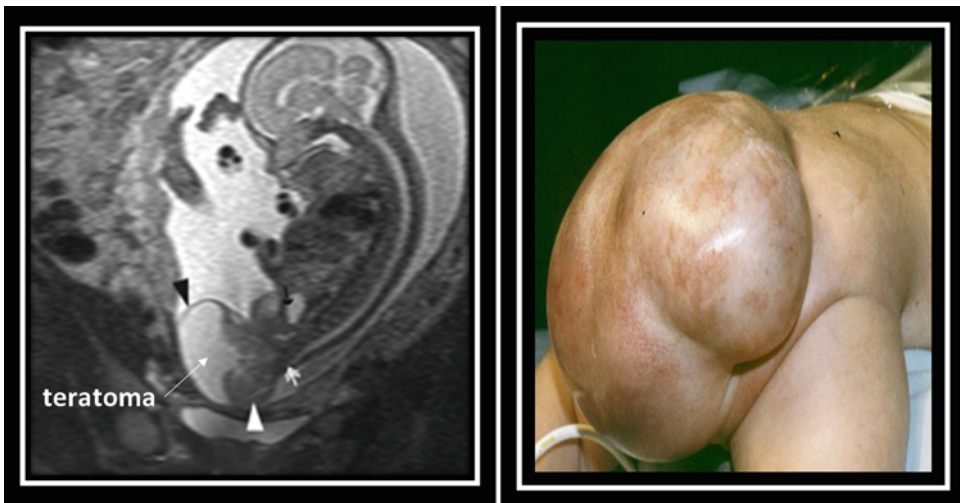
Prenatal MRI and postnatal image of sacrococcygeal teratoma
